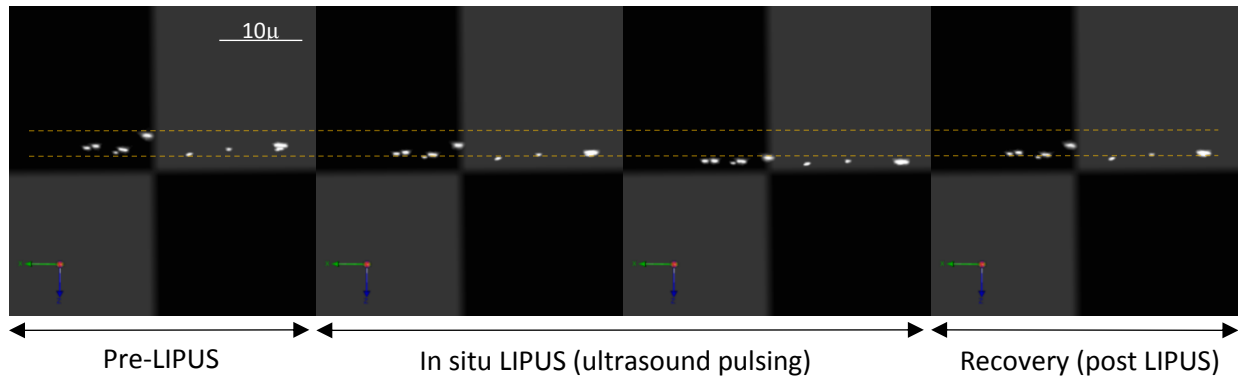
X-Z plane images of GFP actin labeled macrophages before, during, and after exposure to a 1 MHz, 50% duty cycle, 500mV amplitude ultrasound treatment indicate evident Z-plane deformation and displacement with subsequent recovery after exposure ended.
